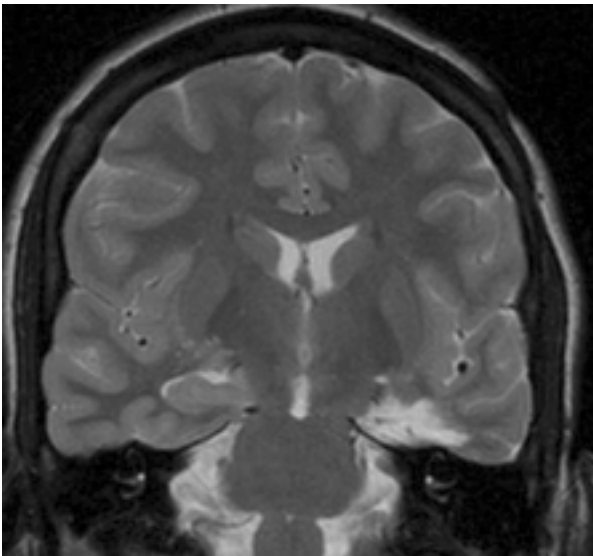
Coronal T2-weighted MRI showing resection of a left hippocampal lesion. The superior and middle temporal gyri are spared and the hippocampus and ventricle were accessed through resection of basal temporal lobe, including inferior temporal gyrus.
